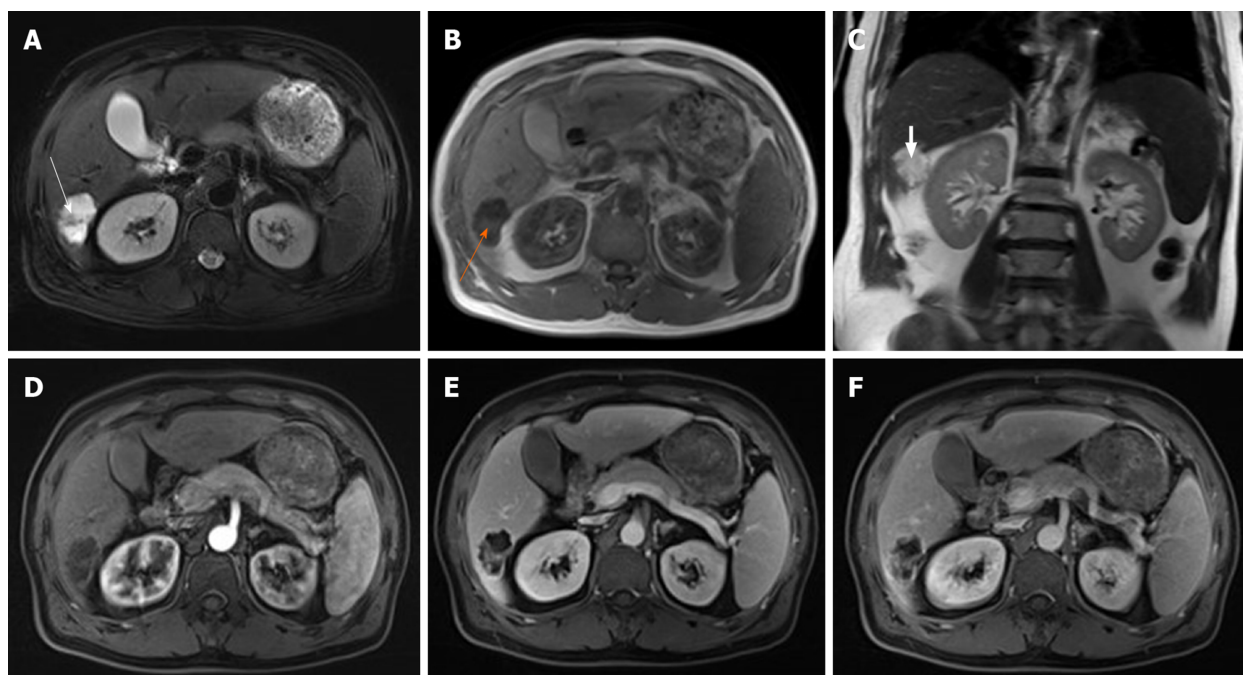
Magnetic resonance imaging at primary clinic visit. A: A magnetic resonance (MR) T2 weighted image (T2WI) axis image showing lobular masses in the posterior lower lobe of the right lobe of the liver with clear borders, a high T2WI signal, intratumor separation with low signal and peripheral capsule with low signal (white arrow); B: An MR T1WI axis image showing the lesion was presented as low signal in T1WI with signals of patches and other (orange arrow); C: A coronal image of T2WI showing that the lesion protruded toward the lower edge of the liver (white arrowhead); D: MR enhanced arterial phase showed that the edge of the lesion and its internal separation are slightly enhanced; E: MR enhanced portal venous phase showed that the edge of the lesion and its internal separation are enhanced; F: MR enhanced delayed stage showed that the edge of the lesion and its internal separation are continually enhanced.
